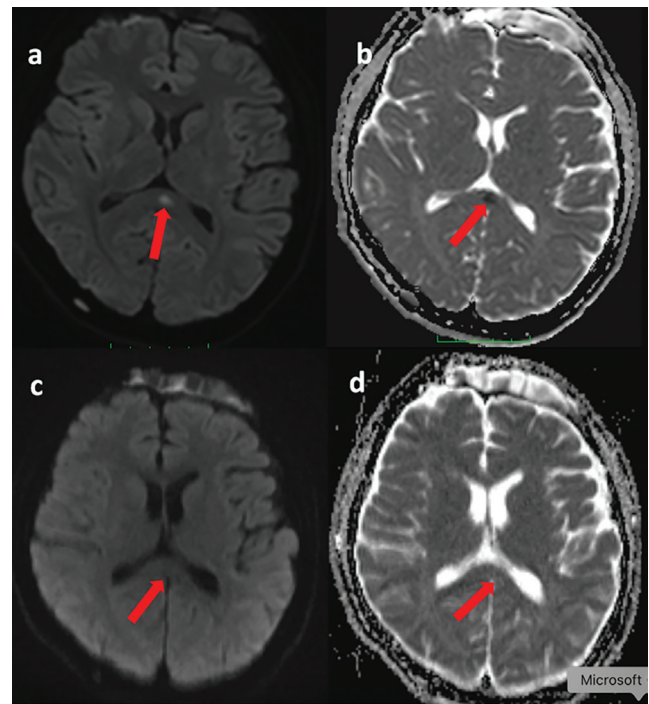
Fourteen-year-old male with pansinusitis and transient splenial lesion of the corpus callosum. Diffusion-weighted MRI obtained on admission (a, b) demonstrates a well-defined focus of restricted diffusion in the splenium of the corpus callosum (red arrow), without corresponding contrast enhancement, consistent with a transient cytotoxic lesion. Follow-up MRI performed 16 days later (c, d) shows complete resolution of the diffusion abnormality, confirming its reversible nature. This transient splenial lesion likely represents a secondary inflammatory or metabolic response associated with systemic infection and sinusitis, rather than direct infectious involvement of the corpus callosum
